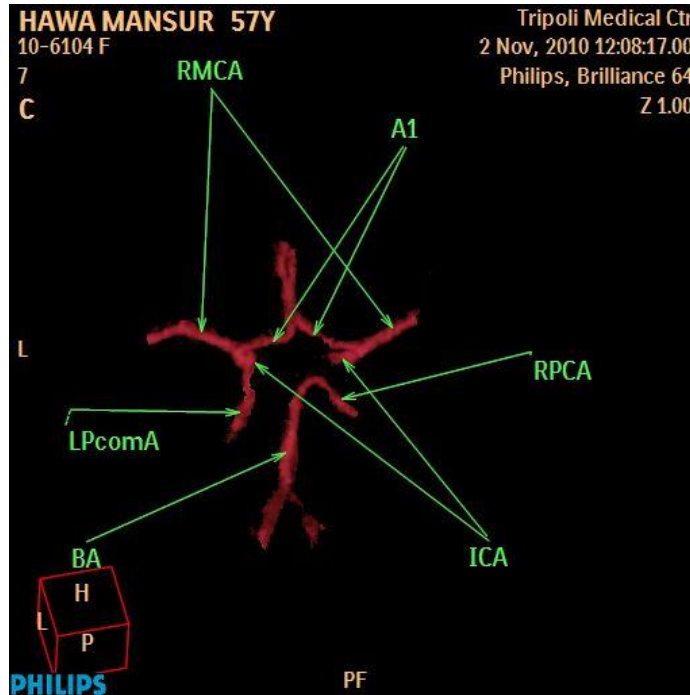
CTA shows missing RPcomA and Lt. complete fetal type posterior circle of Willis.
